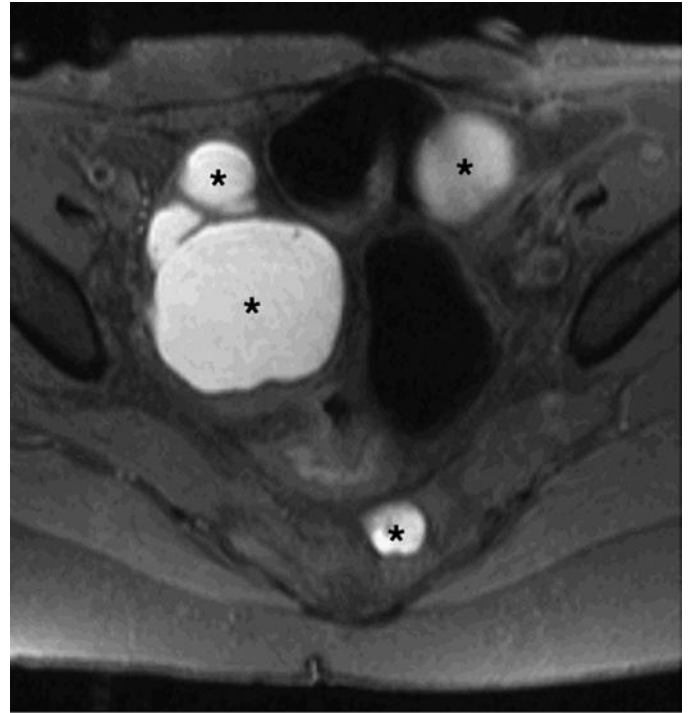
Endometriosis. Axial fat-saturated T1-weighted image of the pelvis demonstrates multiple masses of high signal intensity (*asterisks*), consistent with endometriosis.
